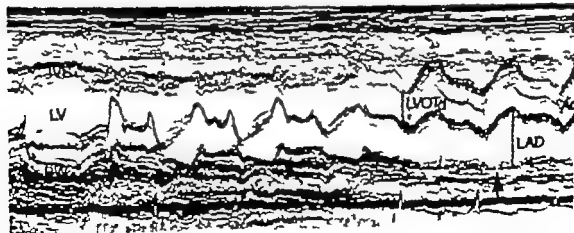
Echocardiogram obtained by M-mode scanning along the longaxis of the left ventricle (LV) up to the aortic root (Ao) in a child without heart disease. The site of measurement of the left ventricular outflow tract dimension in end-diastole (LVOT<sub>d</sub>) is indicated.
